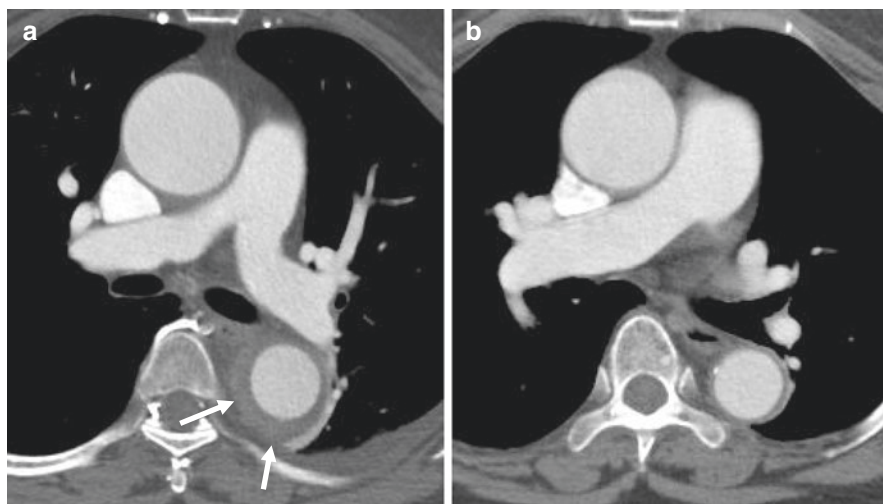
Axial CT images with contrast demonstrate a type B IMH (arrows) in a middle-aged woman (a) that resolved on follow-up imaging 8 months later (b)
